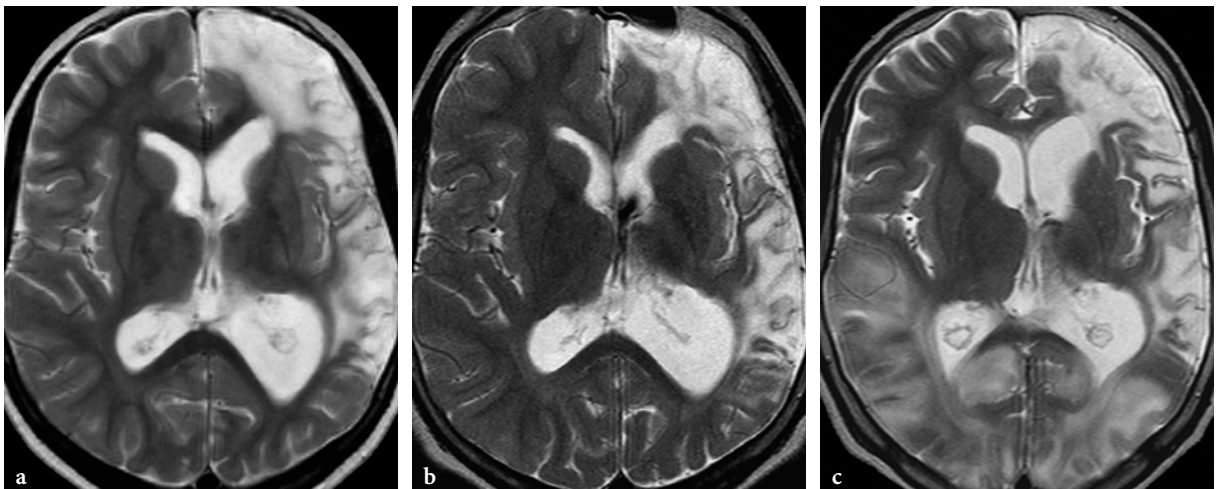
MR imaging findings in MELAS. Axial T2-weighted fast spin-echo images. a Initial MR imaging work-up in an 8-year-old male patient after the first stroke-like episode presenting with right hemiparesis. The left fronto-temporal lesion involves both cortical and subcortical structures and extends to the anterior and middle cerebral artery territories. b Follow-up examination at the age of 12 years, showing interval atrophic changes in the lesion. c The second follow-up study was performed a few months later, when the patient presented with initially right-sided hemianopsia shortly followed by total cortical blindness. New lesions are seen in both occipital lobes, but on the right side the lesion extends to the middle cerebral artery territory as well, in the posterior temporal lobe
